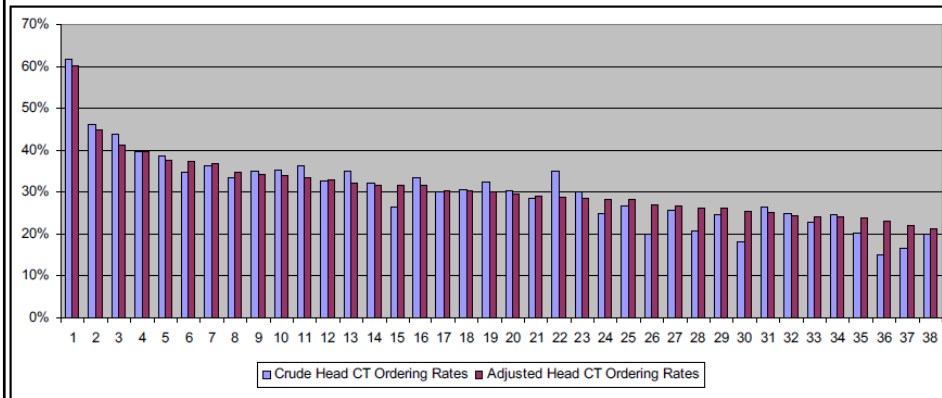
Crude and adjusted head CT ordering rates by physician in patients with atraumatic headache.
